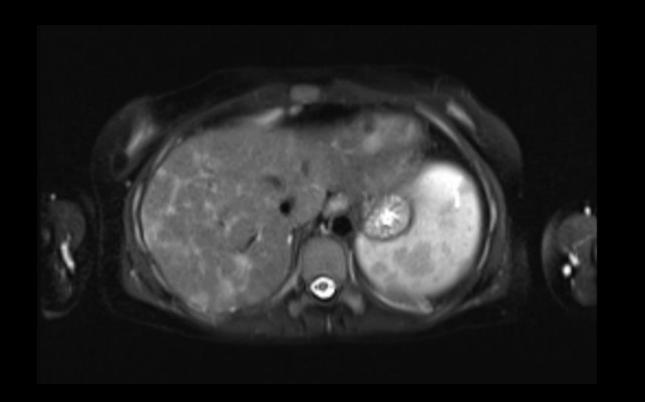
MRI. T2-weighted axial image. Periportal increase in signal intensity on T2-weighted images may reflect the tendency of sarcoid granulomas to appear along the portal tracts. Also note some spleen nodules with low signal, compatible with spleen involvement by sarcoidosis.
